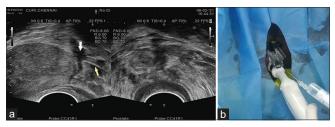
Infiltration of local anaesthesia (a) Trans rectal ultrasound (TRUS) image sagittal and axial view (white arrow – infiltration given in the "Space of Allaway" i.e., between prostatic apical capsule and pelvic floor muscle, yellow arrow – needle tract) (b) TRUS probe with 22-gauge Chiba needle inserted via coaxial needle
